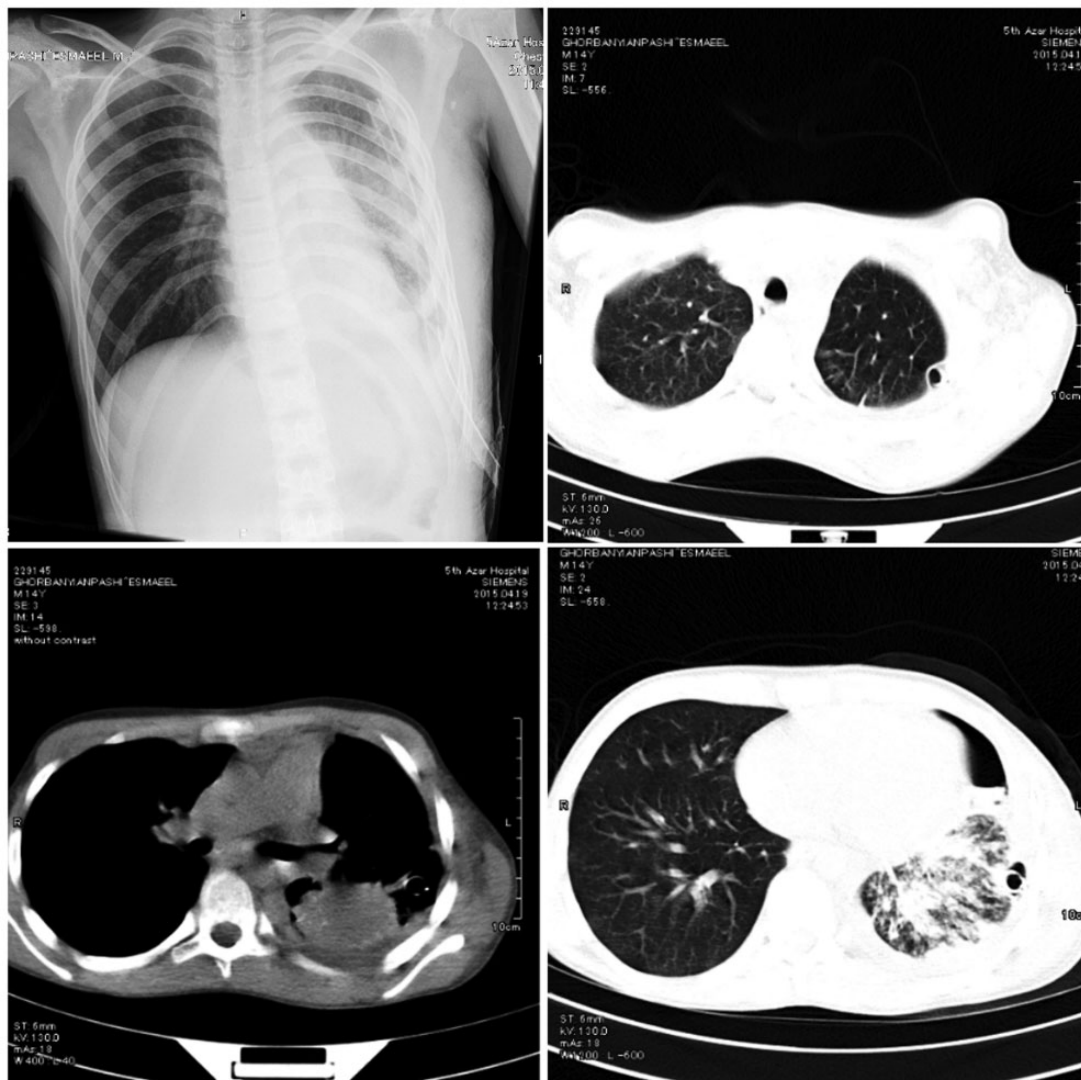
(a) Chest radiograph, (b) parenchymal view of the left upper lobe, (c) mediastinal view of the left lower lobe, and (d) parenchymal view of the left lower lobe after thoracotomy.
